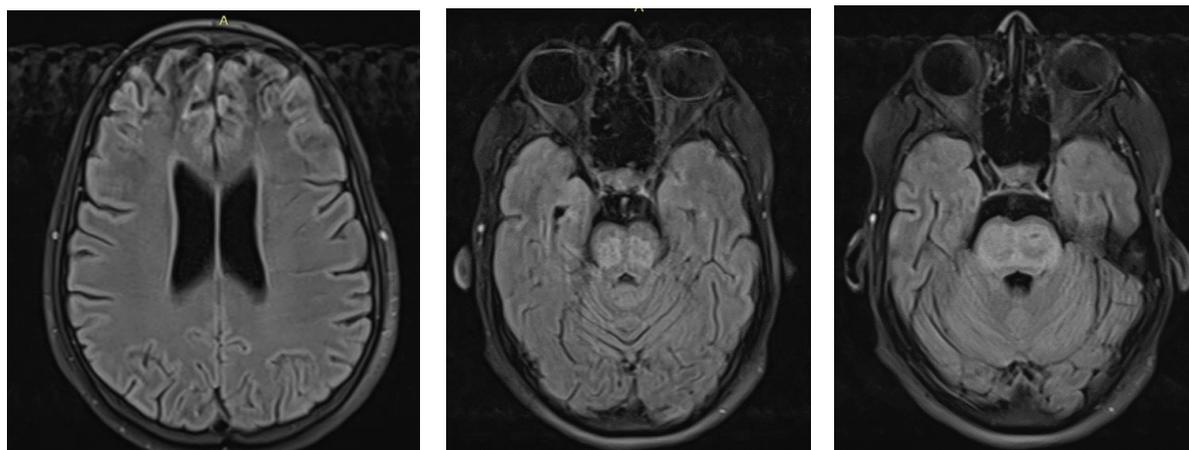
FLAIR sequence: brain MRI showing signal anomalies in Flair hypersignal visible at the frontal cortical level associated with mesencephalic signal anomalies, involving the protuberance, mesencephalic tegmentum, the locus Niger and sparing the red nuclei (arrow)
